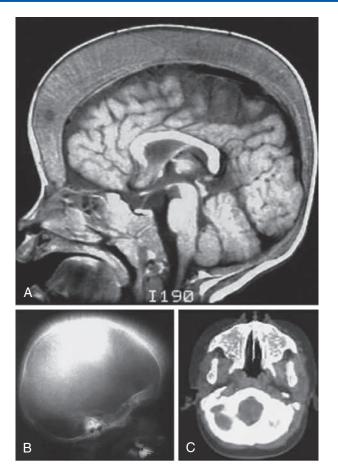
Ineffective erythropoiesis in a 3-yr-old patient who has βthalassemia major and has not received a transfusion. A, Massive widening of the diploic spaces of the skull as seen on MRI. B, Radiographic appearance of the trabeculae as seen on plain radiograph. C, Obliteration of the maxillary sinuses with hematopoietic tissue as seen on CT scan.
